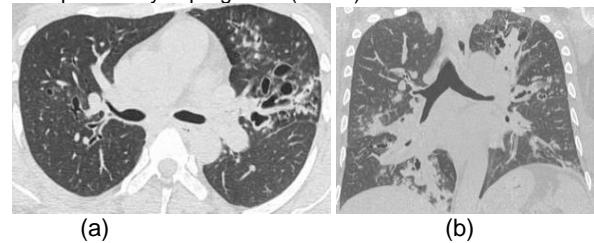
(a) Axial CT image of a young patient with hemoptysis showing bronchiectasis, nodules and patchy ground glass haze. (b) Coronal reformat of CT showing predominant central involvement of bronchiectasis, infiltrates and nodules suggesting Allergic bronchopulmonary aspergillosis (ABPA).
